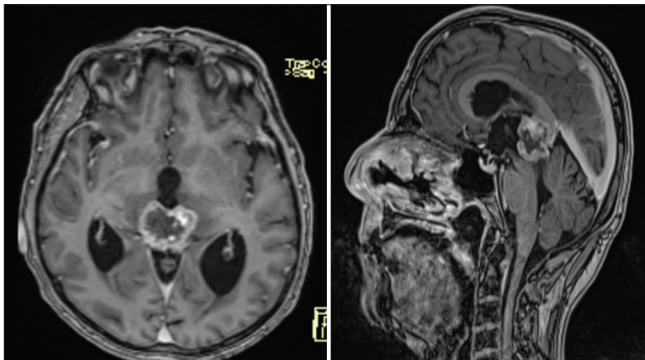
Magnetic resonance imaging brain with gadolinium axial and sagittal views showing a homogeneously enhancing mass with the central necrosis occupying the pineal region causing mass effect on the cerebral aqueduct and secondary ventricular dilatation.
